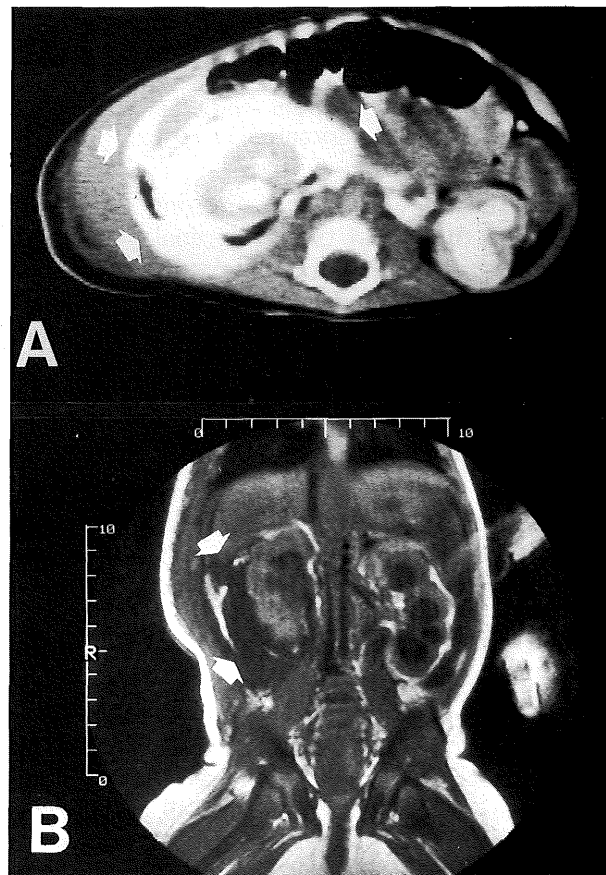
A. Renal CT scan shows a collection of fluid surrounding the right kidney (arrow) by excretory urogram.
